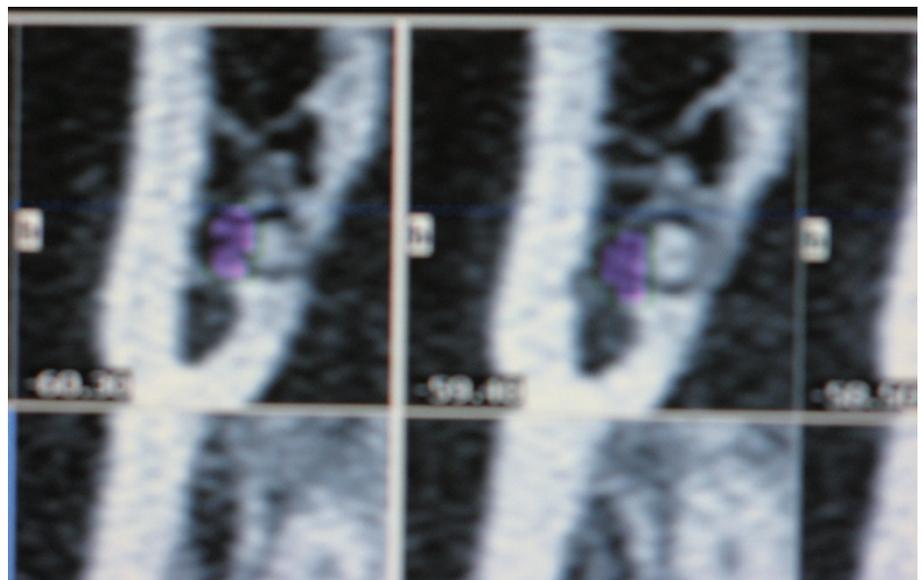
Cone beam CT scan of M3M root proximal to ID canal with additional loss of lingual plate
